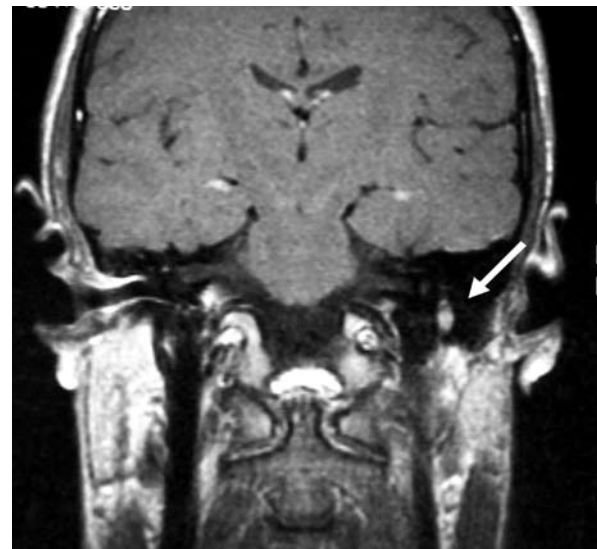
Case 2: contrast enhanced T1 coronal MRI. Enhancing mass in third portion of left Fallopian canal.
